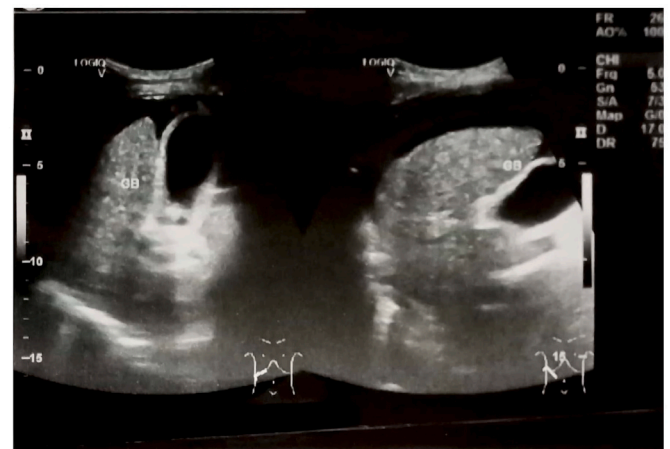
Abdomen ultrasound showing ascites and liver cirrhosis.
